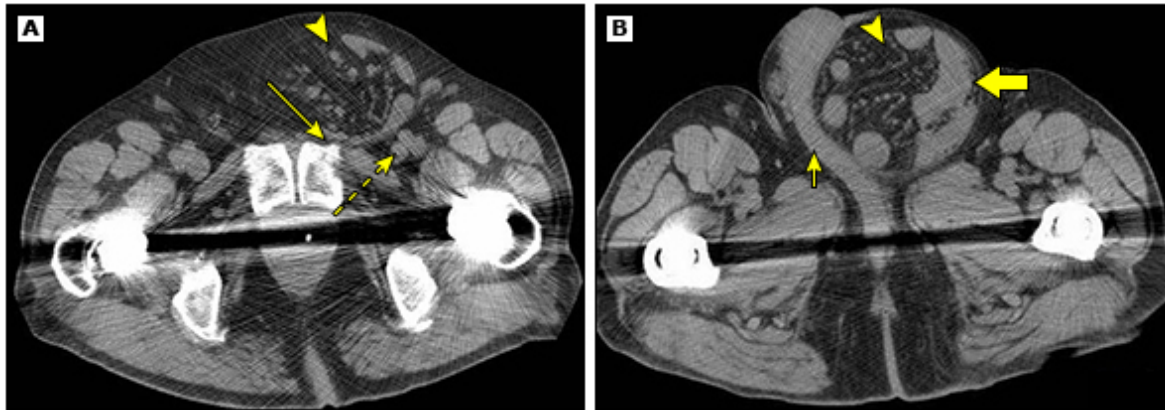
Nonobstructing left inguinal hernia on CT
